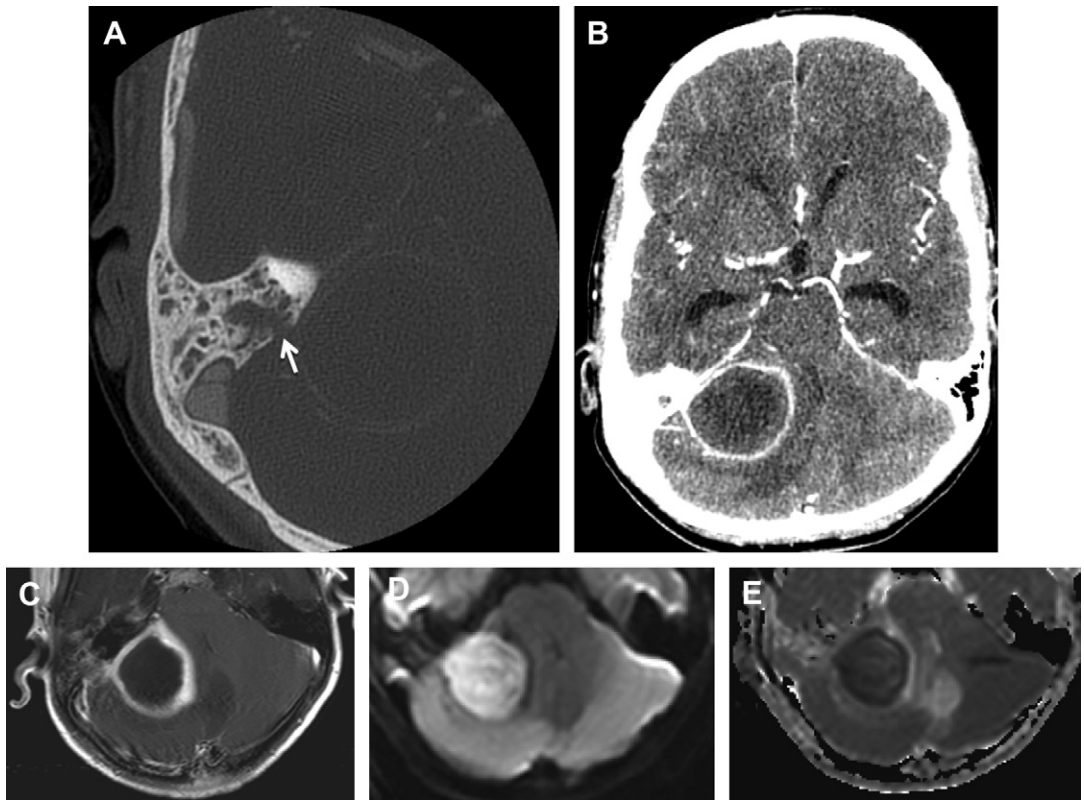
A patient who presented with complaints of earache and fever. (A) Temporal bone CT demonstrates mastoiditis with opacification of the right mastoid air cells and bone dehiscence along the dorsal right petrous temporal bone (*white arrow*). An adjacent ring-enhancing mass is seen in the right posterior fossa. (B) Contrast-enhanced head CT confirms an adjacent round smooth rim-enhancing abscess in the right cerebellar hemisphere. Mass effect displaces the fourth ventricle to the left, and there is associated hydrocephalus. (C) On axial T1-weighted postcontrast MR imaging the abscess demonstrates a ring of enhancement with central T1 hypointense signal. (D) Diffusion-weighted sequence demonstrates central hyperintense signal. (E) On the corresponding ADC map there is central hypointense signal, confirming restricted diffusion in the abscess cavity. (Courtesy of Hemant Parmar, MD, University of Michigan.)
